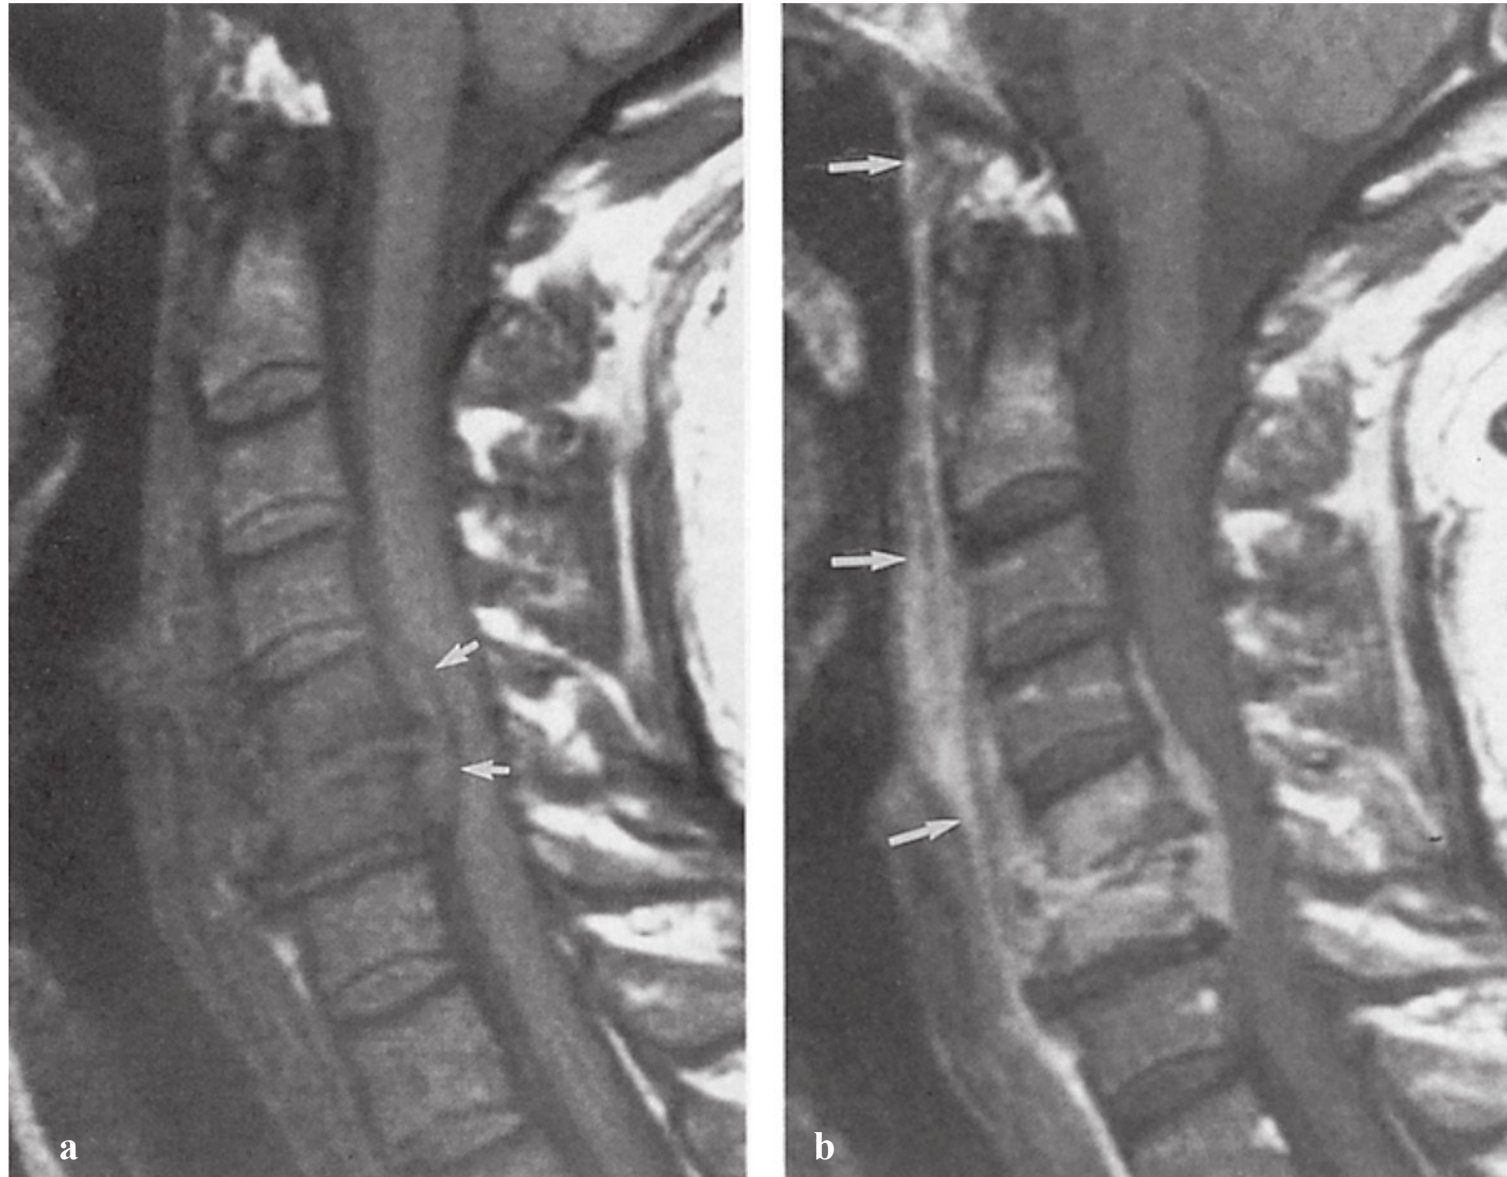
(a,b) Sagittal T1-weighted magnetic resonance imaging demonstrating decreased signal intensity, epidural collection, and irregularity of the cervical spine suggestive of vertebral osteomyelitis. (From Uhlenbrock D. MR Imaging of the Spine and Spinal Cord. Stuttgart, Germany: Georg Thieme Verlag; 2004: Fig. 6.48. Reproduced with permission.)
